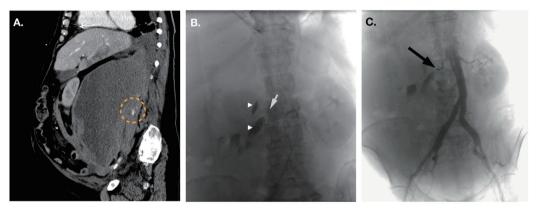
A) Contrast-enhanced abdominopelvic CT with sagittal reconstruction in which a large retroperitoneal hematoma shows focal contrast extravasation (yellow circle) indicating active bleeding. B) Selective arteriography that reveals active arterial bleeding (arrow tips) dependent on L3 right lumbar artery (arrow). C) Control aortography post embolization with coils (black arrow) where the absence of bleeding is confirmed. It is also found a right renal shadow, right renal artery and abdominal aorta displacement to the left due to right retroperitoneal hematoma.
